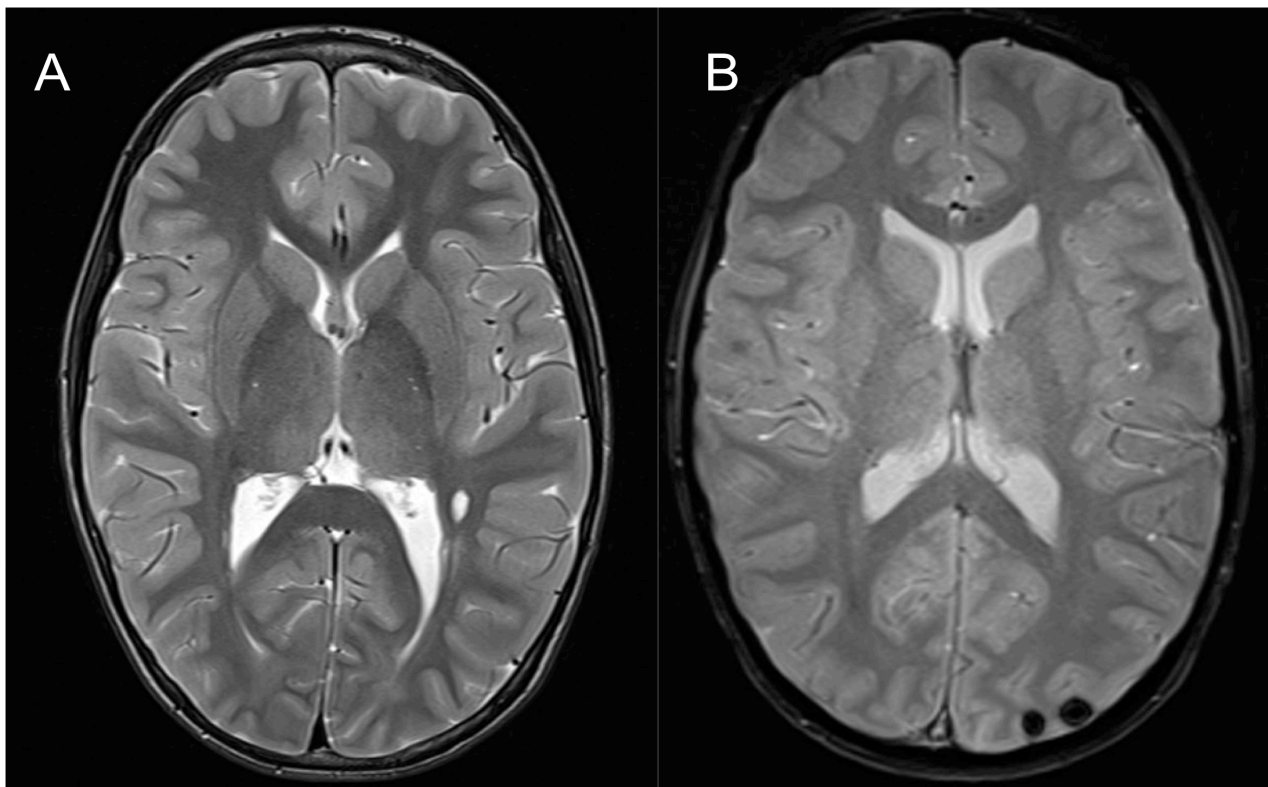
Case 5. Axial T2-weighted MRI showing a brain cyst in the paraventricular left white matter [A] and axial T2-weighted MRI demonstrating 2 left occipital cavernomas [B]*
